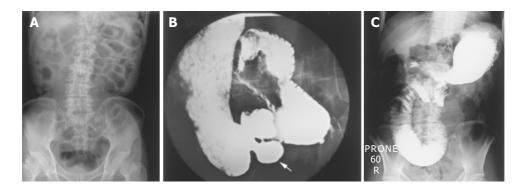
A plain X-ray of the abdomen showing dilatation of the small intestine, especially the proximal jejunum (A). B and C: An upper GI oral contrast study showing multiple diverticula in the duodenum and proximal jejunum (the white arrow, (B) and dilatation of the proximal jejunum (C).
